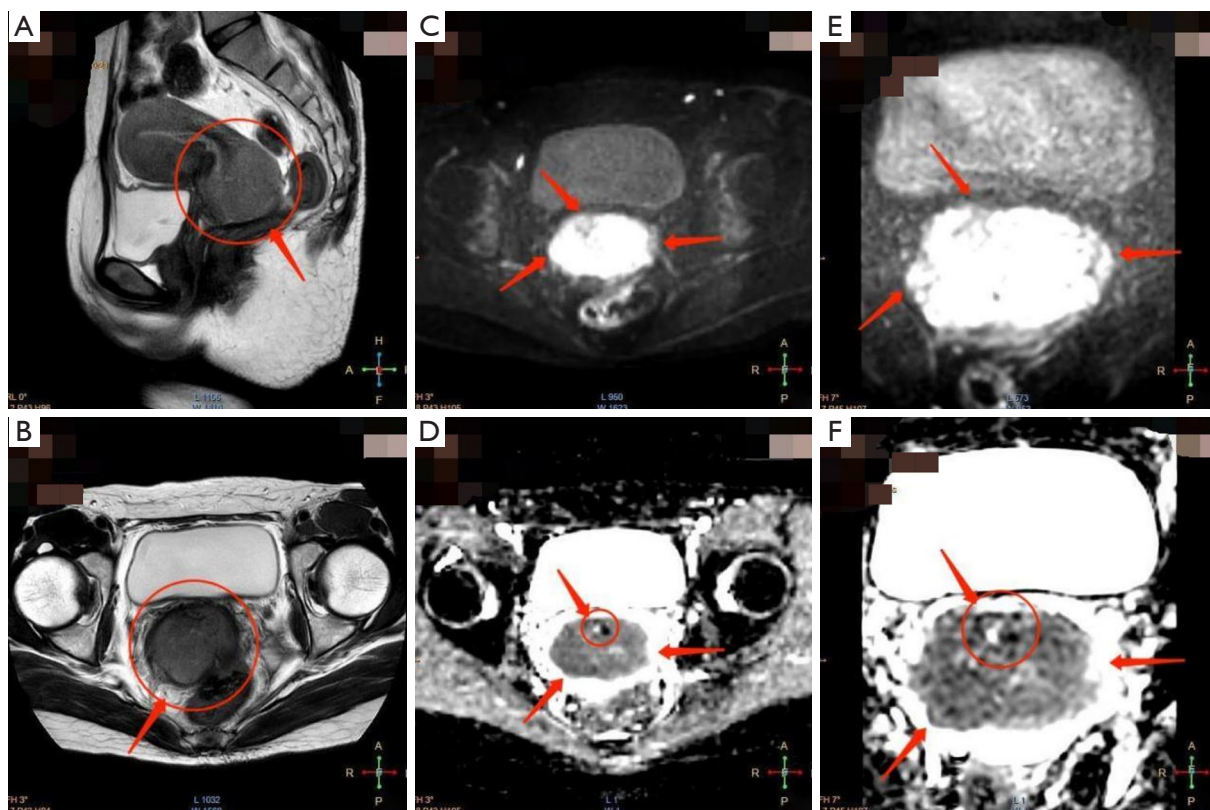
Qualitative image quality score comparison. (A) Sagittal T2WI image. (B) Transverse T2WI image. (C) c-FOV DWI high b value map ($b=1,000 \text{ s/mm}^2$). (D) c-FOV DWI ADC map. (E) r-FOV DWI high b value map ($b=1,000 \text{ s/mm}^2$). (F) r-FOV DWI ADC map. FIGO staging of a 38-year-old woman with stage IIA2 squamous carcinoma of the cervix. An irregularly shaped soft tissue mass in the cervix (indicated by the red arrow) is seen on the T2WI image with the equivalent signal. Comparing the high b value and ADC maps of the two sequences (indicated by red arrows), the r-FOV DWI shows more anatomical details, with clearer lesion margins and a more detailed inhomogeneous signal. T2WI, T2 weighted image; c-FOV DWI, conventional field-of-view diffusion-weighted MR imaging; r-FOV DWI, reduced field-of-view diffusion-weighted MR imaging; ADC, apparent diffusion coefficient; FIGO, Federation International of Gynecology and Obstetrics.
